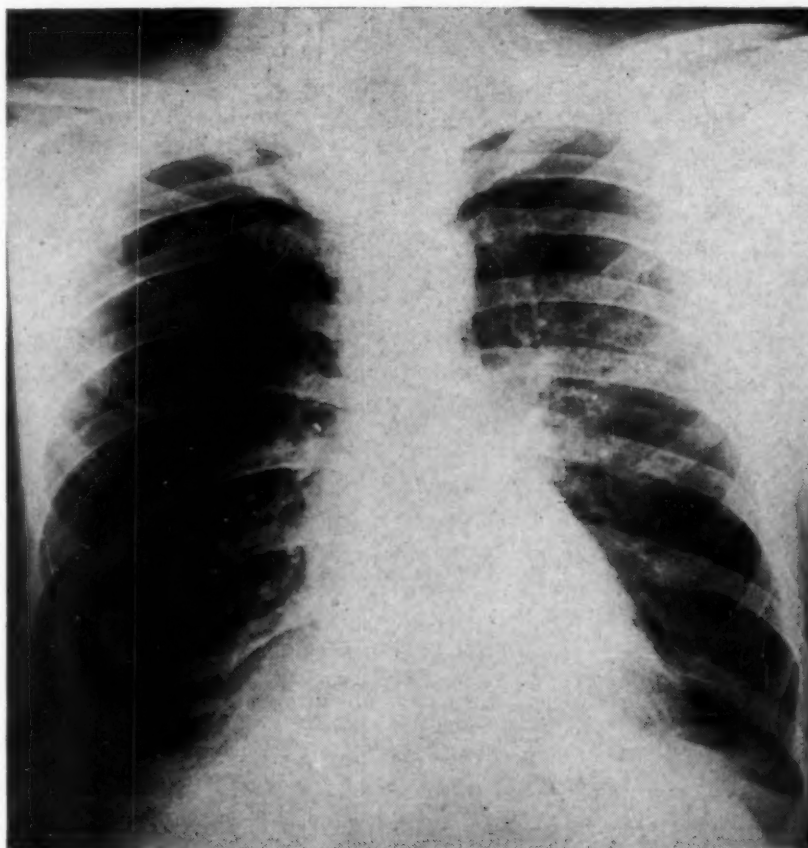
P. A. x-ray of chest. Note the disease in the right lung as shown by the fine strands traversing the space in wide sweeping curves. Disease in the left upper is also seen as fine strands, shorter than on the opposite side.
